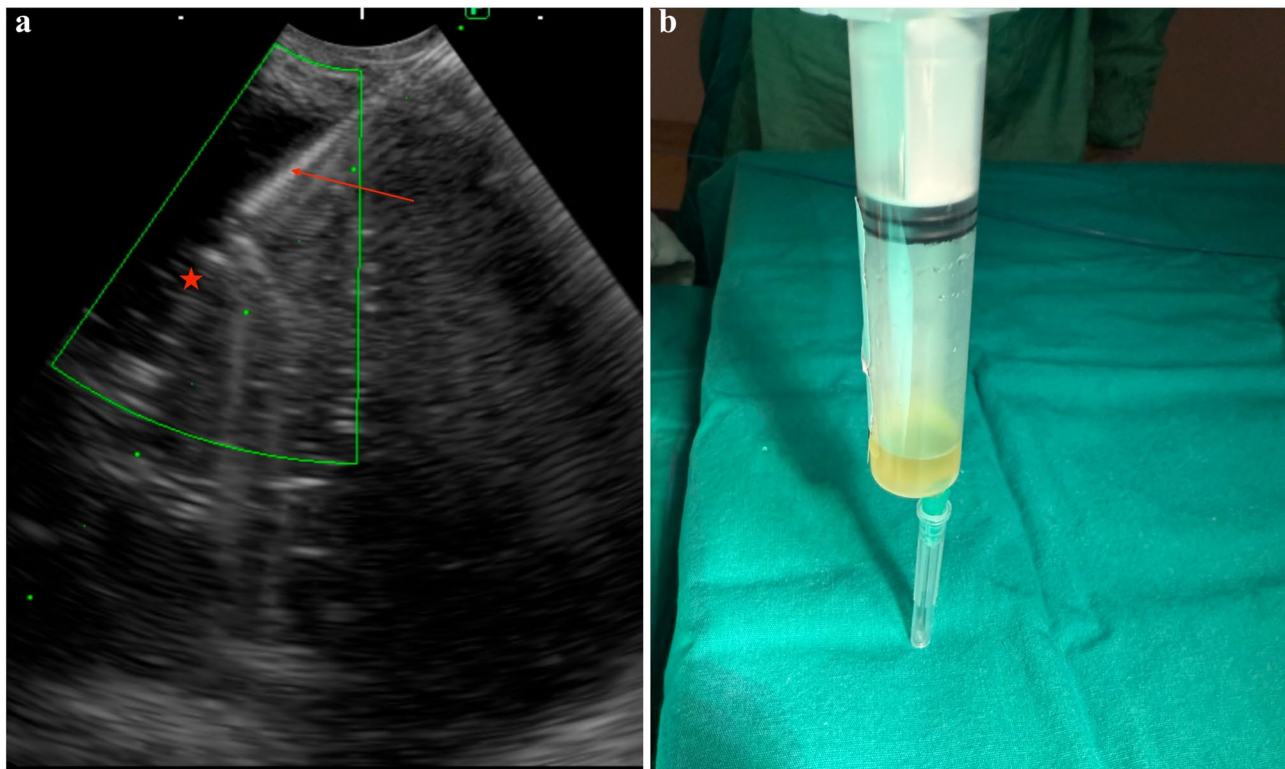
(a) EBUS view showing the pleural pocket accessed via the right paratracheal route (asterisk). This unconventional approach was selected due to limited transthoracic access following right superior bilobectomy. (b) The aspirated pleural fluid was sampled for pathological and microbiological analysis
